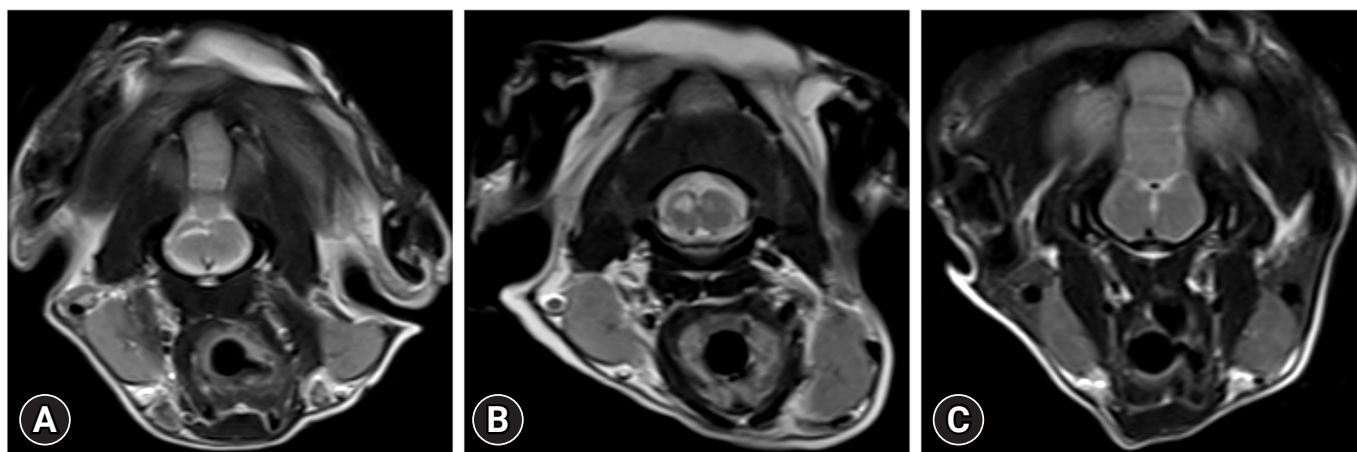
Transverse T2-weighted images on magnetic resonance imaging of the caudal brainstem. Note the 3 shapes of syringobulbia including slit-like (A), bulbous (B), and vertical linear (C).
